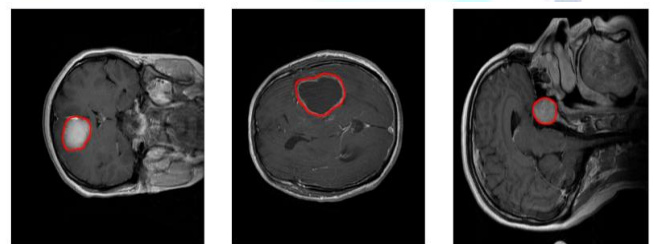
Examples of MRI images of the T1-CE MRI image dataset. Left: coronal view of a meningioma tumor. Center: Axial view of a glioma tumor. Right: sagittal view of a pituitary tumor. Tumor borders have been highlighted in red.
